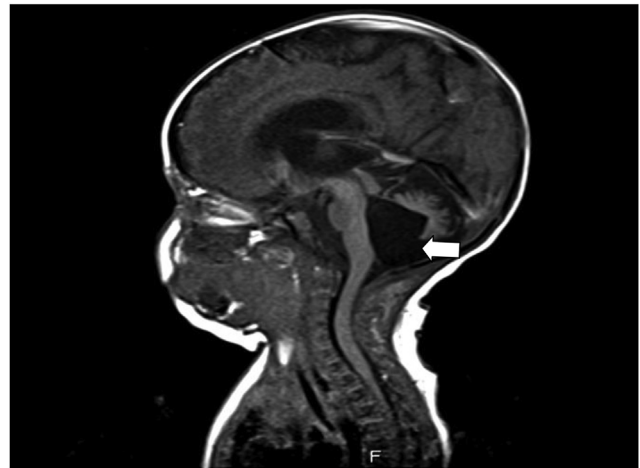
Sagittal view of brain MRI, showing features suggestive of the Dandy–Walker variant with communicating hydrocephalus, and no torcula, tentorium elevation or posterior fossa expansion.
